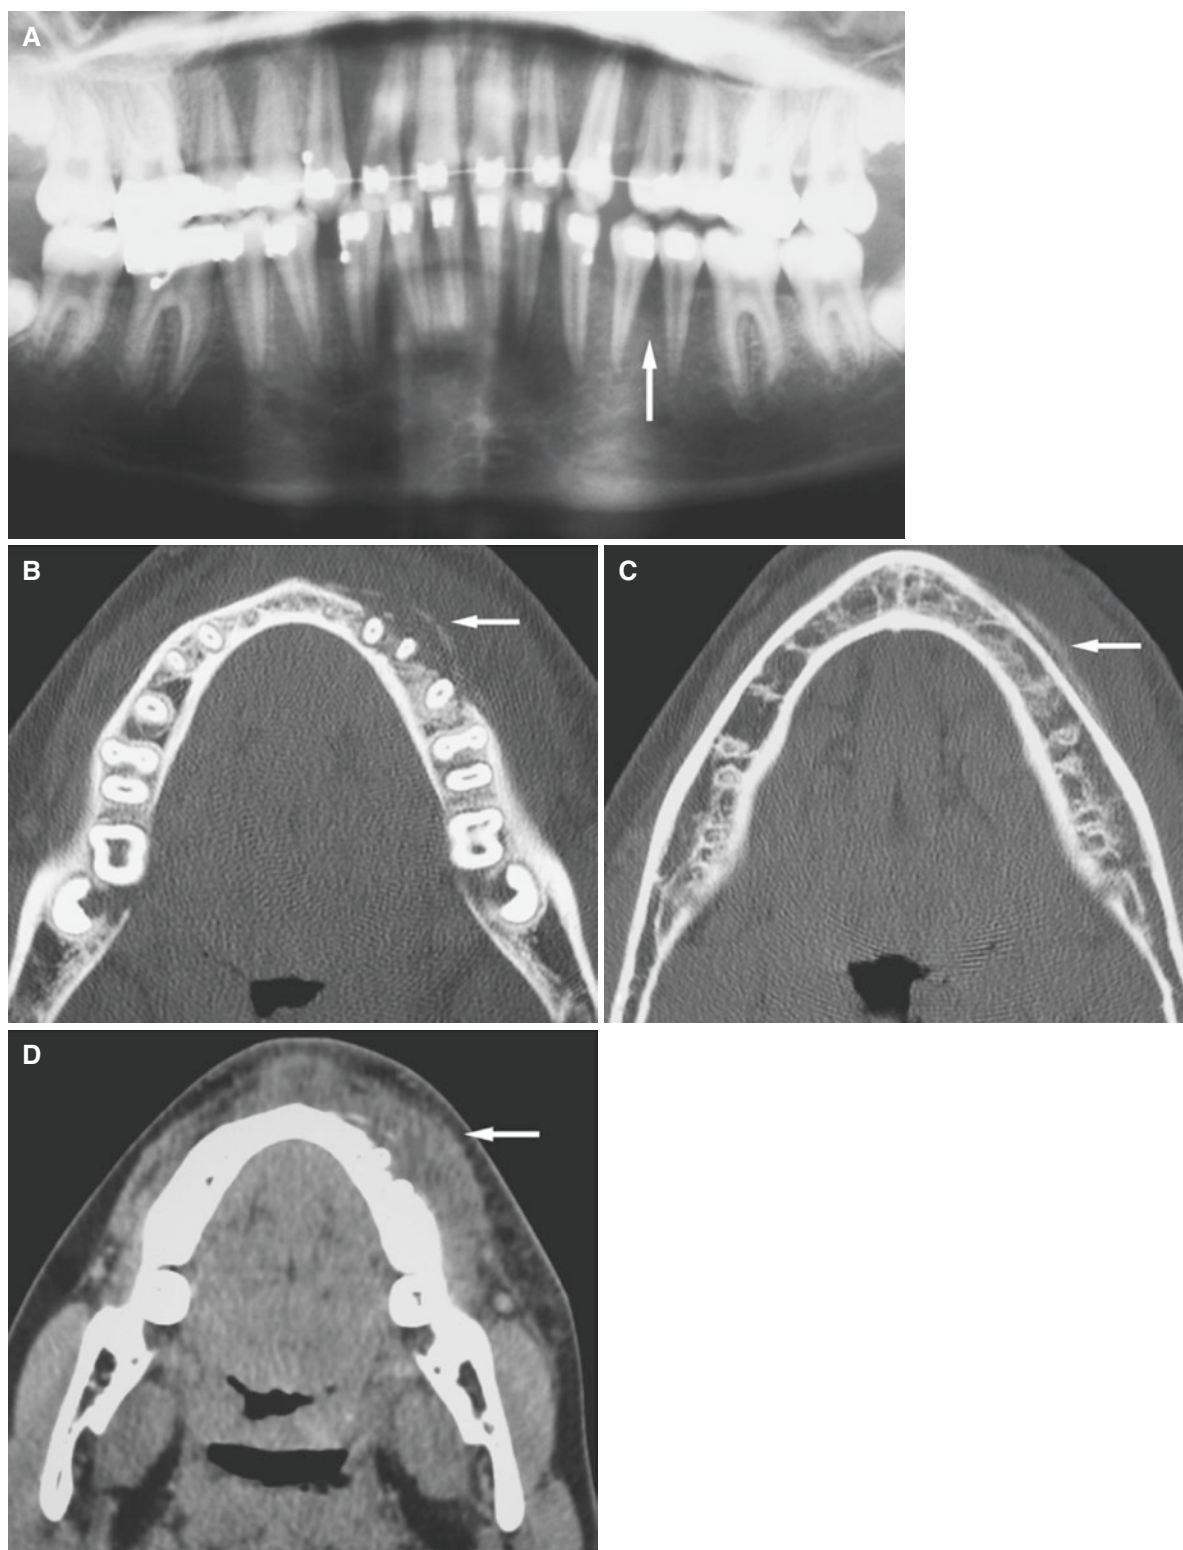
Osteomyelitis with periostitis, mandible; 12-year-old female with 3-week history of gingival swelling that began less than a week after orthodontic adjustment of braces. (A) Panoramic view shows diffuse destruction in premolar area (*arrow*). (B) Axial CT image shows
